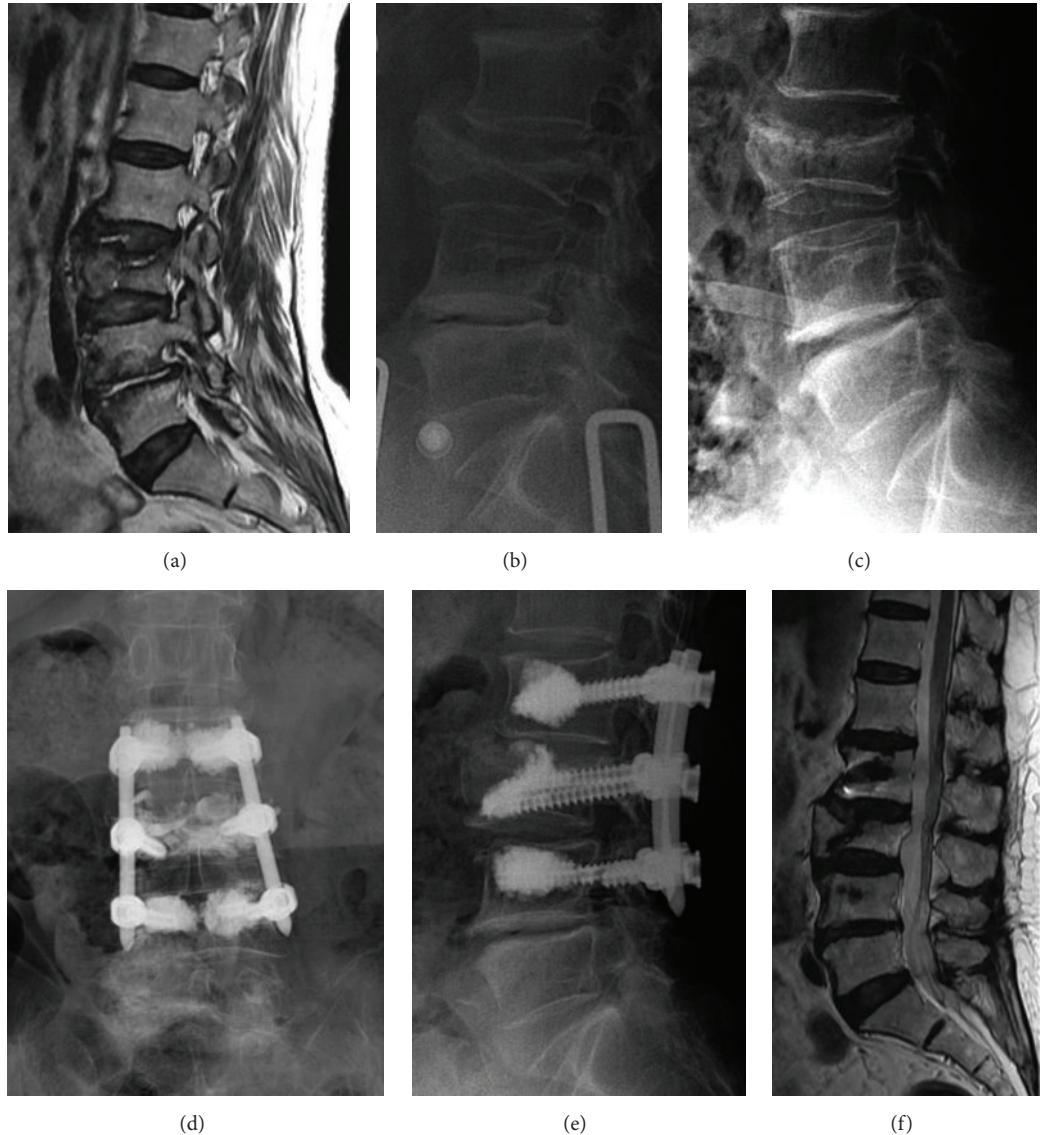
Preoperative MRI and X-ray show a L3 compression fracture with osteonecrosis ((a) and (b)). The compressed L3 body was reexpanded after postural reduction (c). The compressed vertebral body with osteonecrosis was well healed and still restored in spite of left L4 pedicle screw fracture at the 24-month follow-up ((d), (e), and (f)).
